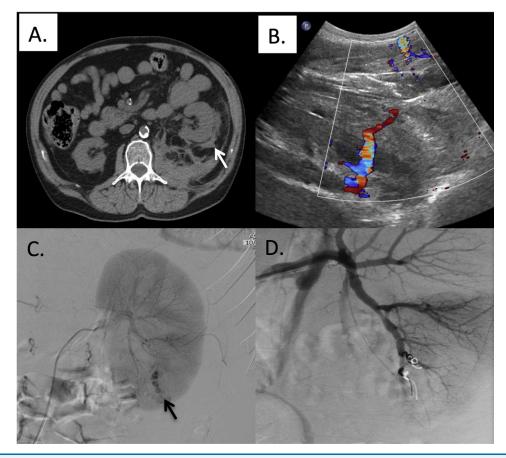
Bleeding as a complication of kidney biopsy. (A) Computed tomographic image with arrow pointing to a hematoma with resulting retroperitoneal hemorrhage. (B) Doppler ultrasound shows active extravasation of blood after biopsy. (C) Fluoroscopy shows active extravasation of contrast from a site of persistent bleeding. (D) Coiling of a vessel that was actively bleeding in panel C.
